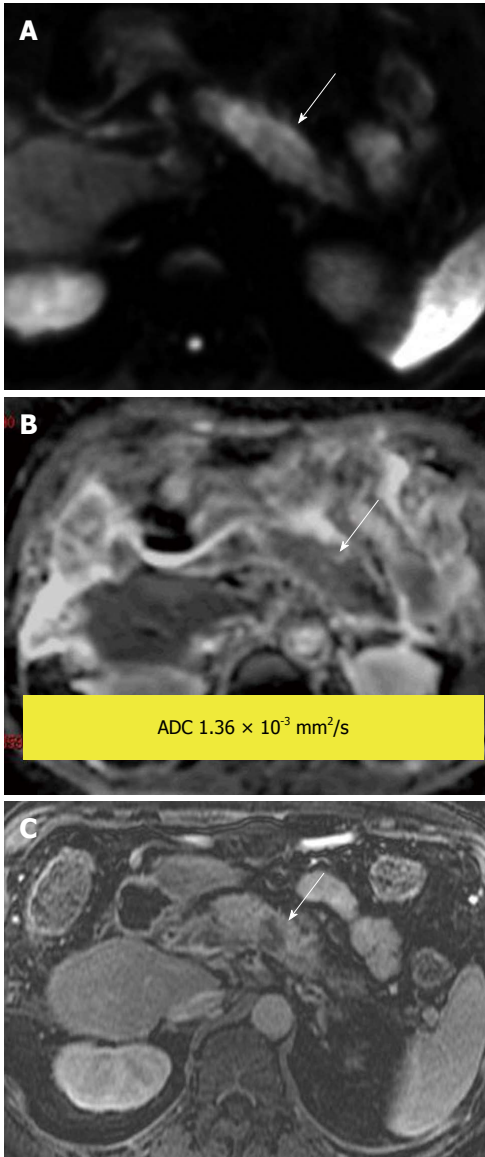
Pancreatic ductal adenocarcinoma. Hyperintense mass demonstrated on (A) diffusion-weighted image due to impeded diffusion, confirmed by a hypointense signal on (B) apparent diffusion coefficient map. Findings are supported by a (C) post-gadolinium T1-weighted image that shows the tumor to be hypo enhancing compared with the enhancing pancreatic parenchyma.
